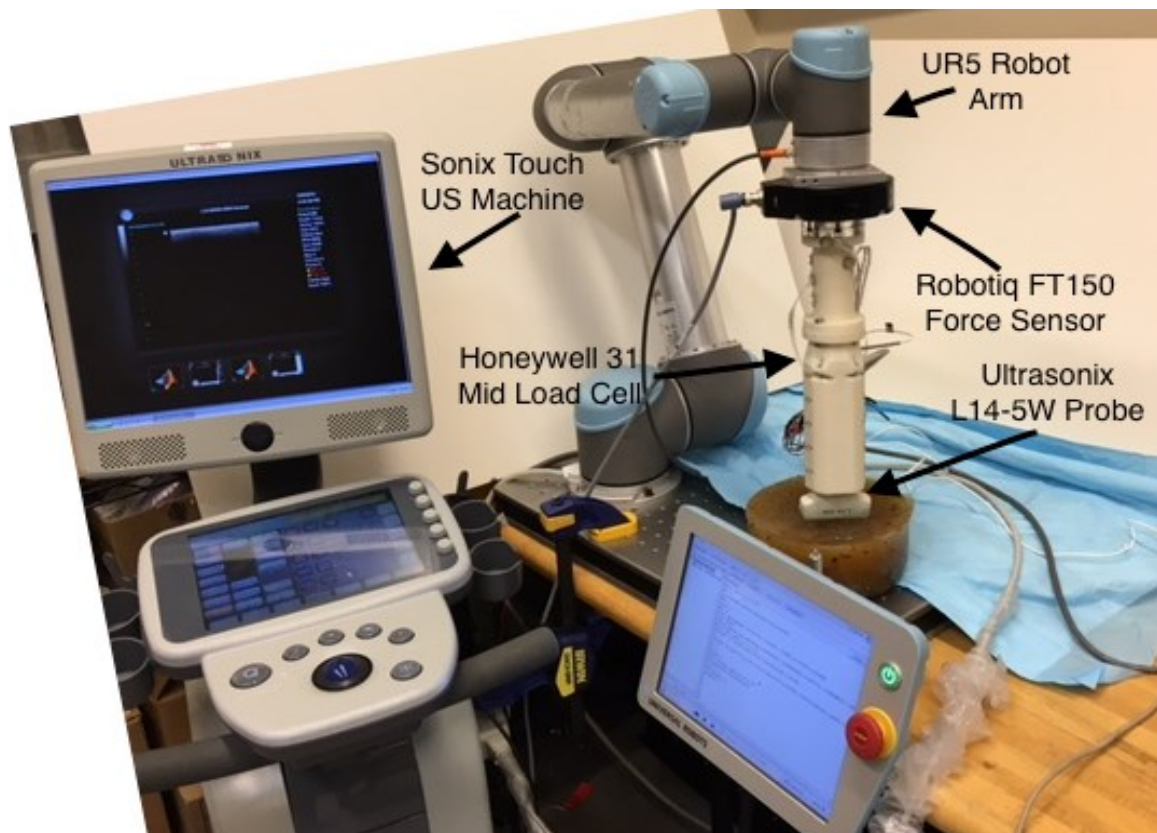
Integrated system setup consisting of UR5 robotic arm, Robotiq FT-150 force/torque sensor, Honeywell Model 31 Mid Load Cell and Ultrasonix ultrasound probe and machine.
